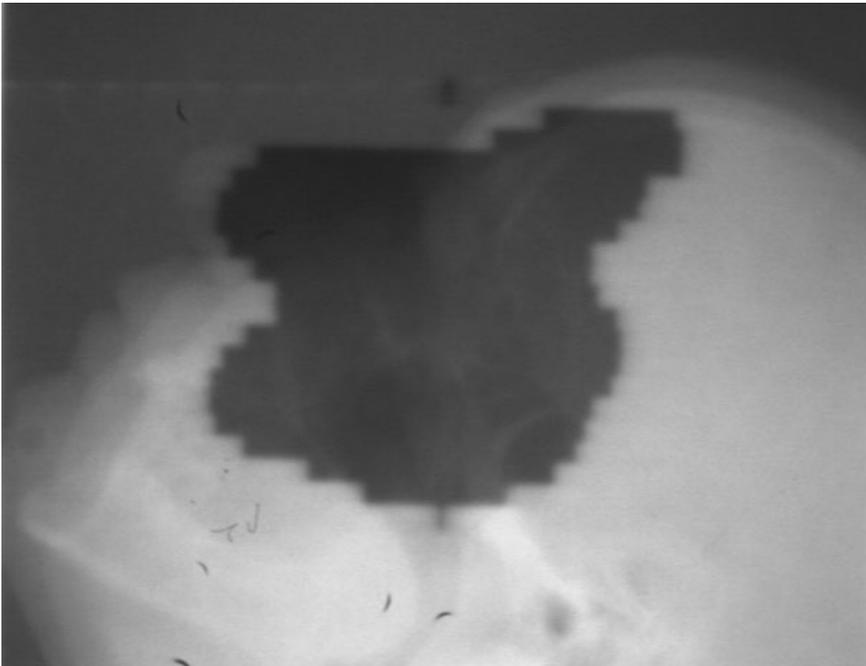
Port film for a lateral field used in a treatment of the maxillary sinus. This double exposure radiograph allows the physician to visualize both the treatment field and the surrounding anatomy.
